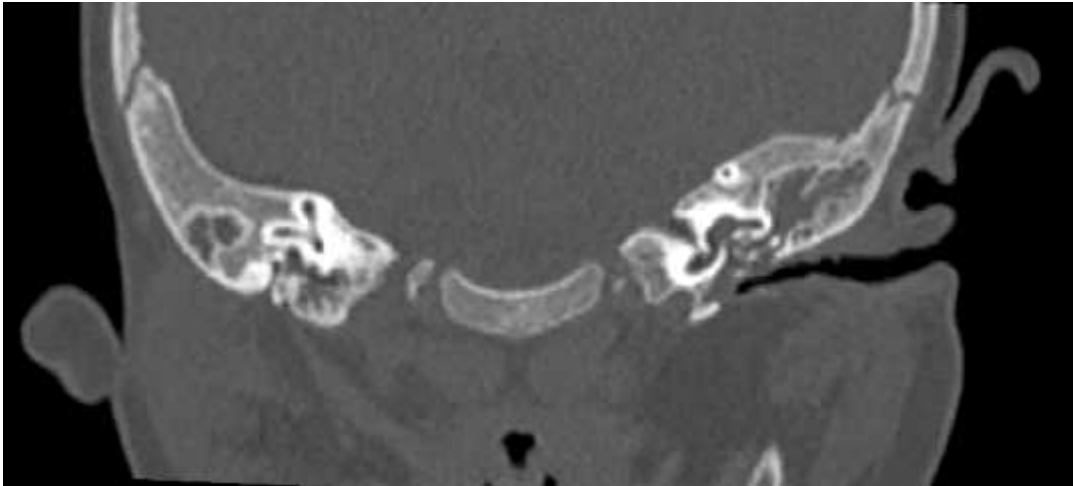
HRCT Axial and coronal reformatted image shows hypoplastic right pinna. There is aplasia of right external auditory canal. Middle ear and inner ear appeared well formed. There was soft tissue density noted within the middle ear cavity bilaterally suggestive otitis media.
